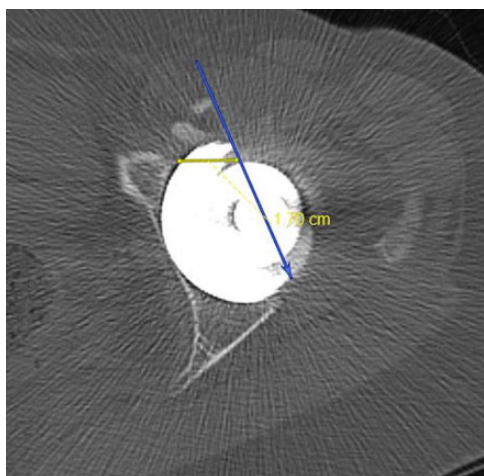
Axial pelvic computed tomography scan showing acetabular cup prominence with a large, overhanging edge. Note the new bone formation near the anterior rim of the acetabulum, in proximity to the iliopsoas.
